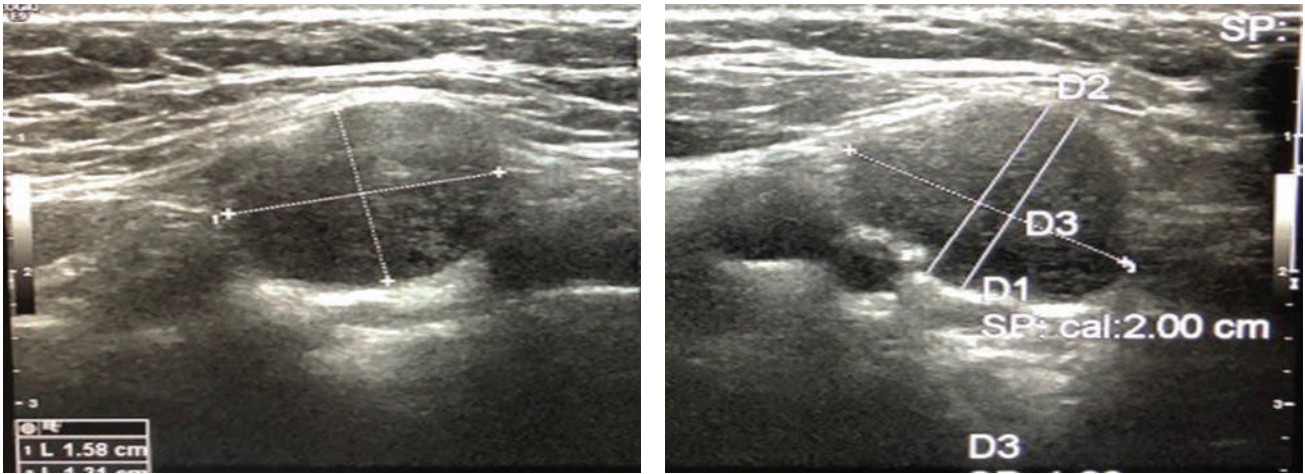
Ultrasound of the neck: 1.8 x 1.3 x 1.6 cm enlarged lymph node in the right superior jugular chain (level II), with x 10 magnification.
